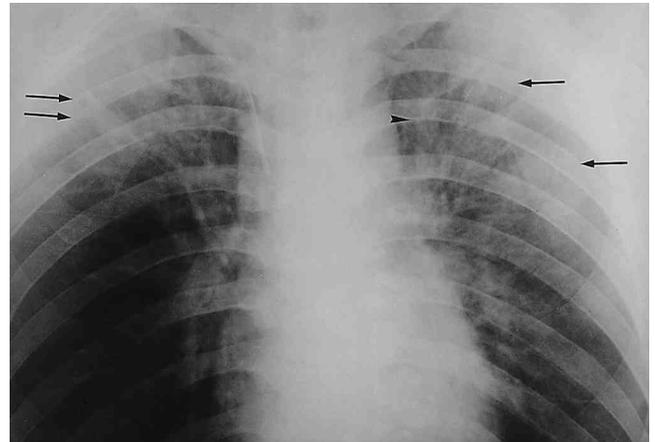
Parenchymal lung injury by smoke inhalation (mixed alveolar and interstitial pattern) in a 40-year-old man. Chest radiograph obtained six hours after exposure to a house fire shows alveolar edema (arrows) in both upper lung and left perihilar area in an asymmetrical distribution. Prominence and fuzziness of the vessels (arrowhead) in the upper lobes are also seen. Central venous pressure was 4-6 mm Hg.
